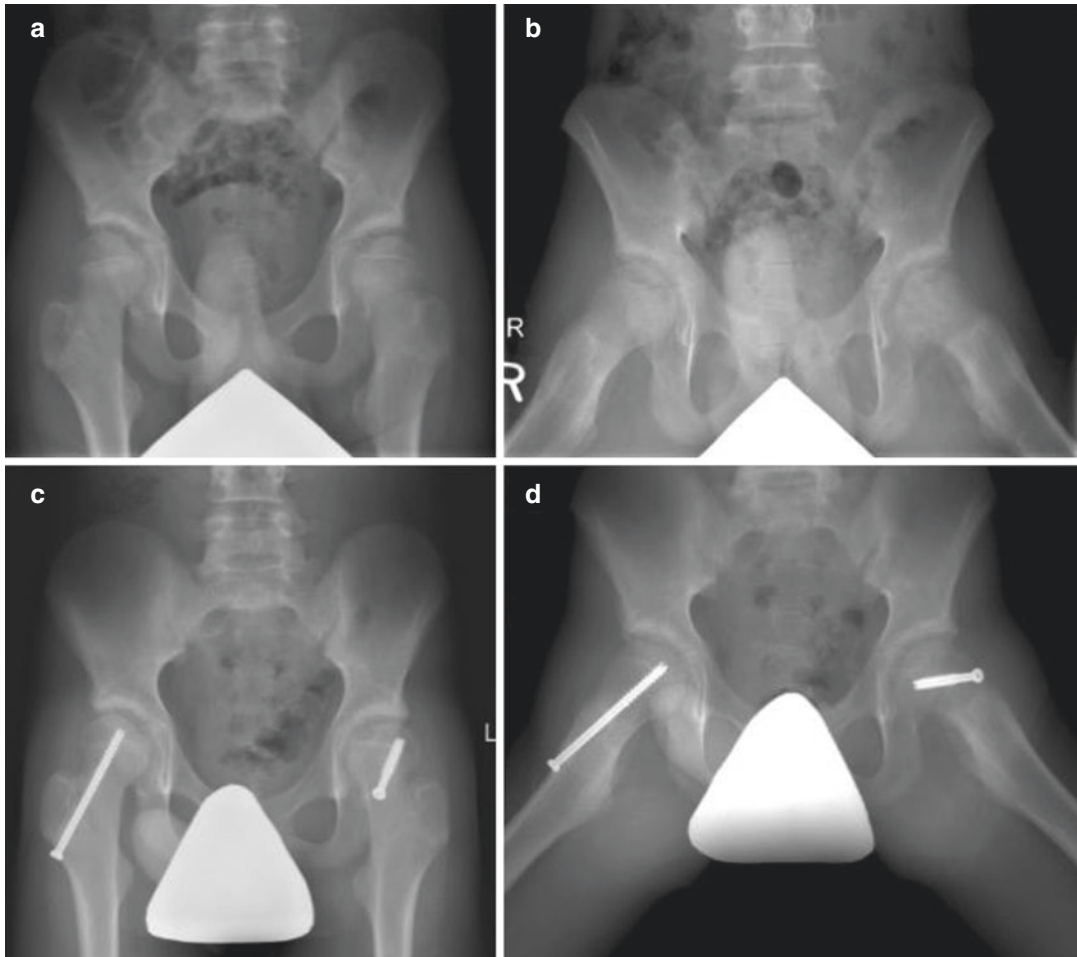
13-Year-old boy with symptomatic left valgus SCFE. (a, b) Anteroposterior (AP) and frog-leg lateral pelvic X-rays demonstrating relative anteromedial displacement of the femoral epiphysis on the left and lateral physeal tilt on the right (asymptomatic) side. (c, d) Post-operative AP and frog-leg lateral pelvic X-rays showing *in situ* screw placement of the left valgus SCFE and prophylactic
